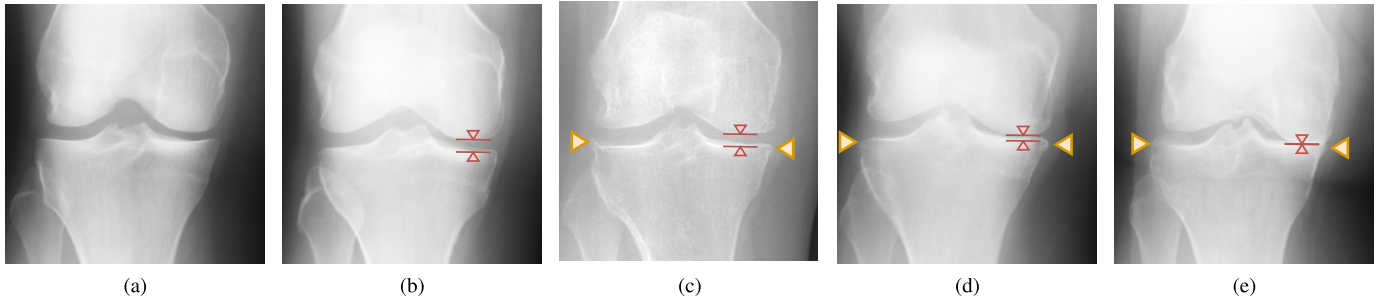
Samples of knee radiographs. Joint space narrowing and osteophyte features are indicated by red and yellow marks respectively. (a) KL 0: A healthy knee without OA, (b) KL 1 (Doubtful OA): Potential joint space narrowing, (c) KL 2 (Mild OA): Clear evidences of osteophytes, as well as slight reduction of joint space, (d) KL 3 (Moderate OA): Osteophytes grow and joint space narrowing progresses badly, and (e) KL 4 (Severe OA): Besides osteophytes, joint space is reduced so severely that the tibia and the femur are connected.
